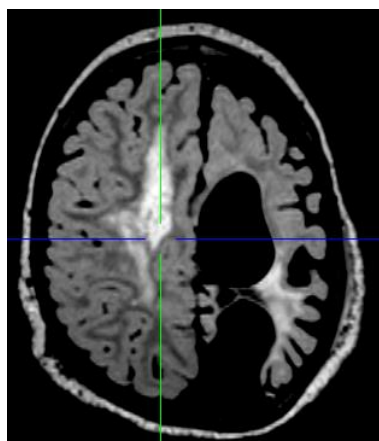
Rightsided white matter hyperintensity in postoperative MRI, Pat. 1, at age three years and nine months. FLAIR, transversal section.
